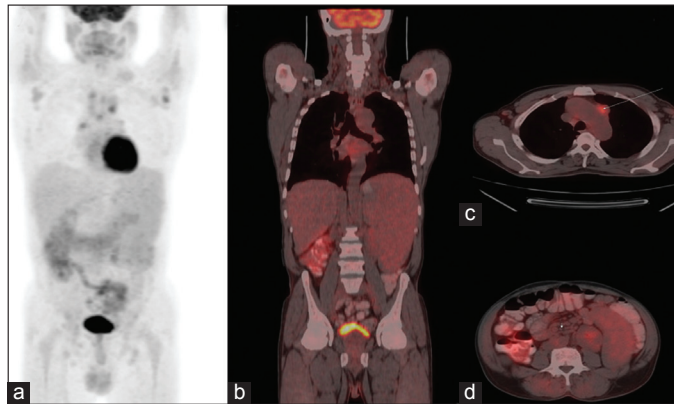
Maximum intensity projection image (a) shows faint F-18 fluoro-deoxy-glucose (FDG) uptake in mediastinal, b/l axillary lymph nodes and mild diffuse uptake in enlarged spleen. Coronal images showing mild F-18 FDG uptake in enlarged spleen. Transaxial images showing mild F-18 FDG uptake in mediastinal lymph node (hottest lesion with maximum standardized uptake value [SUV_{max} 4.3]) and retroperitoneal lymph nodes (SUV_{max} 2.3). This image shows a rare case of diffuse large B cell lymphoma (DLBCL) with very low F-18 FDG uptake. Though DLBCL is considered routinely F-18 FDG avid about 3% of the cases with DLBCL can be lowly F-18 FDG avid.^[3] This image also highlights the need of baseline scan to demonstrate F-18 FDG avidity of the involved lymph nodes for better assessment of response after chemotherapy
